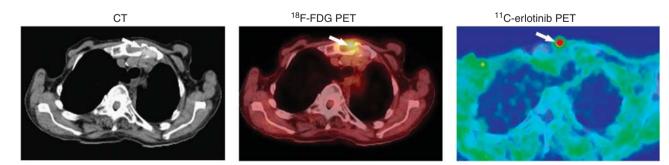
Figure I Accumulation of ¹¹C-erlotinib in a bone metastasis from a NSCLC. Left: transaxial slices of contrast-enhanced CT: middle: ¹⁸F-FDG PET/ low-dose CT; right: ¹¹C-erlotinib PET/low-dose CT. A 79-year-old patient (no. 12) had NSCLC with metastasis to the sternum as shown on CT (arrow left figure). Both ¹⁸F-FDG and ¹¹C-erlotinib accumulated in the metastatic lesion (arrows middle and right figures).
